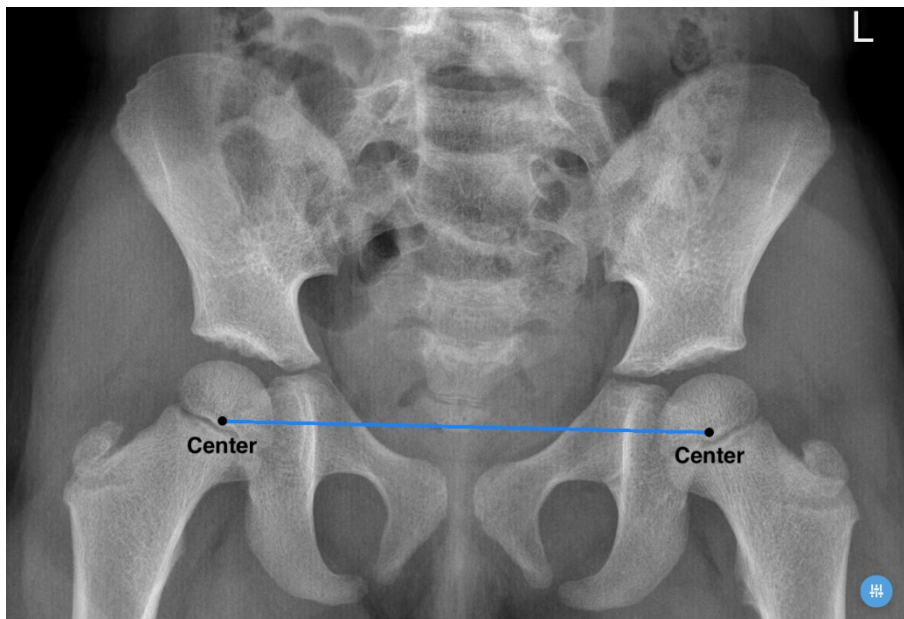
Identification of the CE angle in the radiograph
